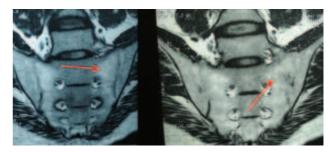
MRI of SI joints of the index case (41-year-male) showing bilateral sacroiliitis (red arrows).
